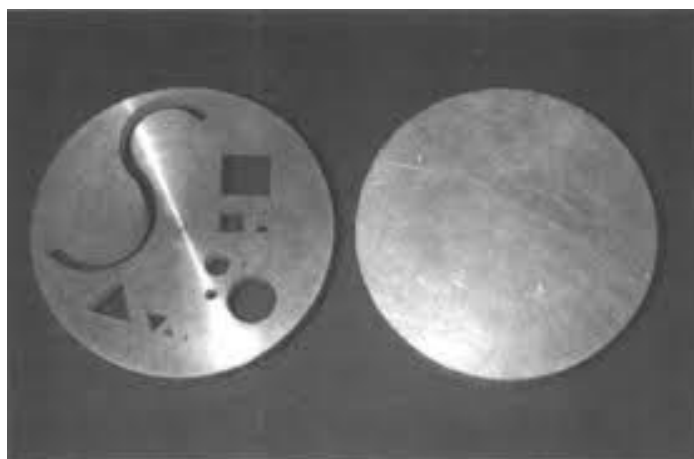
CT scanning test model. (Source: Neel and Klosterman, 1998)
